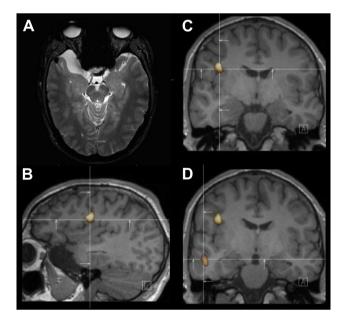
Cerebral MR and ictal SPECT images of patient 1. (A)
